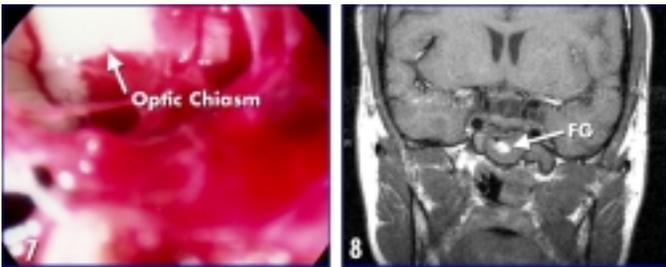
(Left): Post-removal view of the chiasm; Figure 8 (Right): Postoperative MRI with fat graph (FG).
